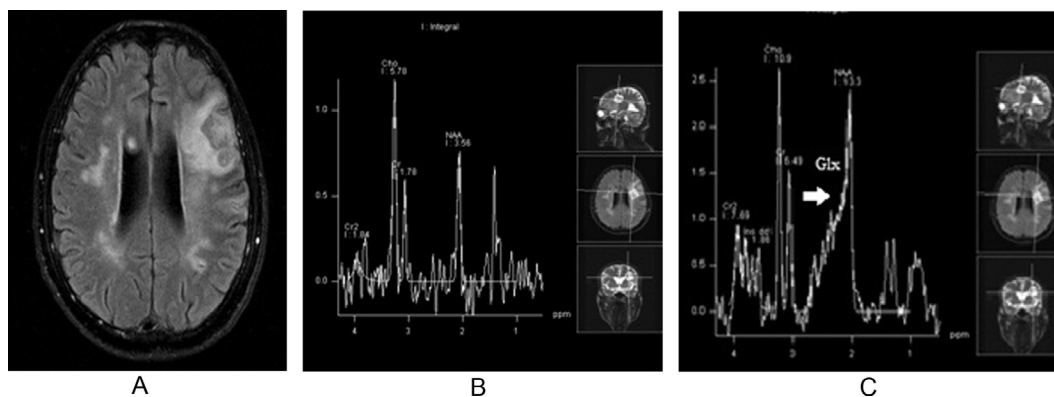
Male patient 57 years old with subacute hemorrhagic infarction presented with right sided weakness: findings: (A) axial T2 FLAIR images revealed left cortical and subcortical high signal intensity lesion with multiply intralesional areas of altered signal intensity, (B & C) MRS at long and short TR revealed elevated Cho, reduced NAA/Cr with high Glx (thick white arrow) and lipid lactate peak.
